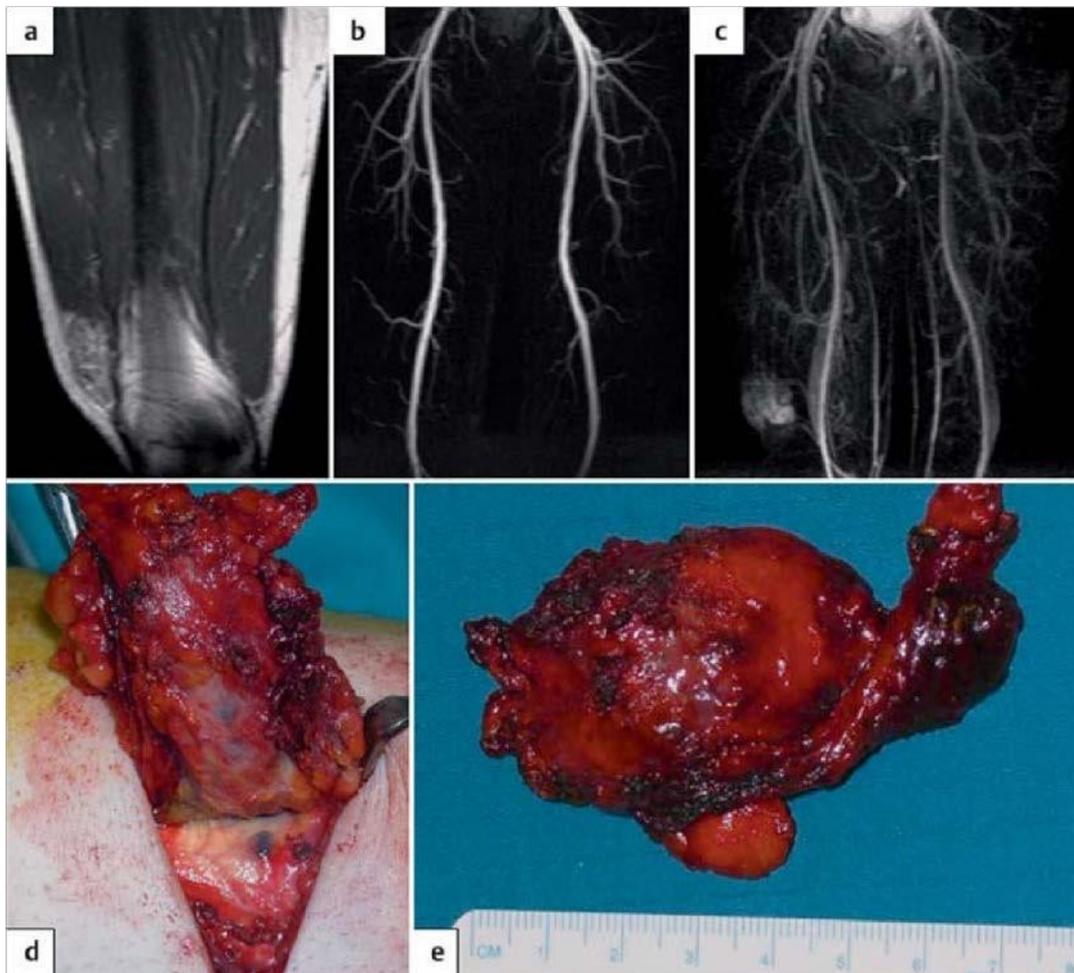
a,b,c,d,e. A 17 years old boy suffered many years with pain in the area of the right knee joint, (a,b,c) magnetic resonance imaging shows a large localized venous malformation, (d,e) surgical resection of the malformation was performed.
